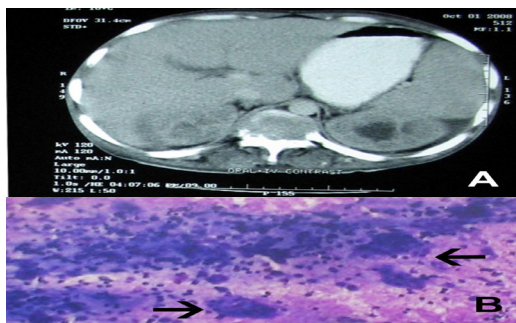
A) CT Scan of Abdomen Showing a Bone Tumor Destroying Body and Posterior Elements of L2 vertebra. B) FNAC of the Tumor Showing Numerous Osteoclastic Giant Cells (arrows) and Mononuclear Stromal Cells in a Case of Giant Cell Tumor of Spine (Leishman Giemsa x100).
